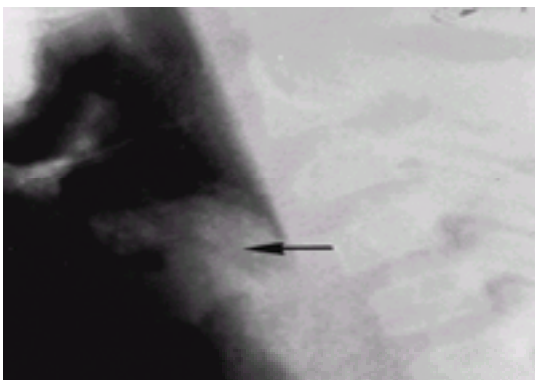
Lateral neck radiograph demonstrating soft-tissue density (*arrow*) at level of larynx. Direct laryngoscopy revealed this to be papilloma.
